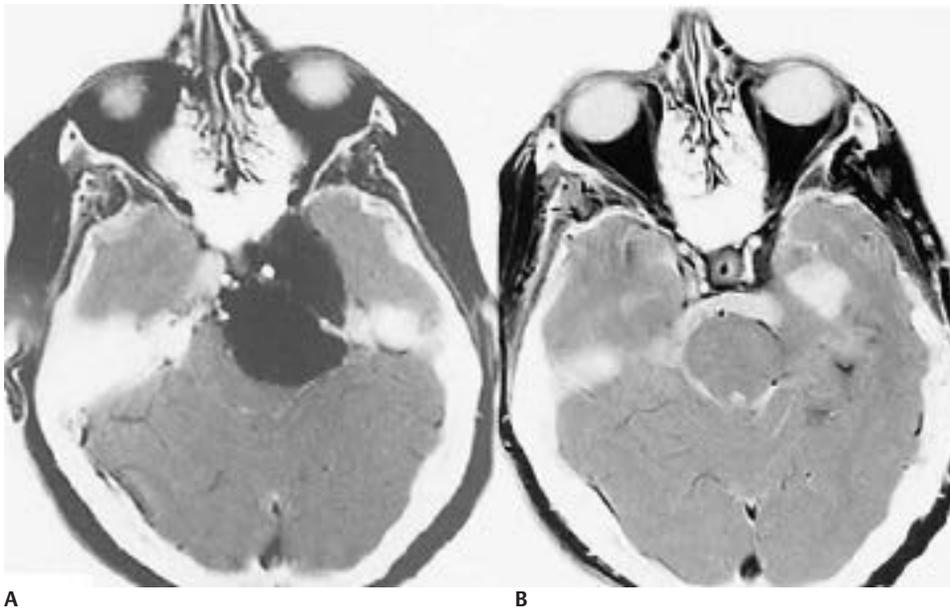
A sphenopetroclival meningioma with invasion of the cavernous sinus. A skull base approach facilitated total removal. (A) Preoperative enhanced axial MRI. (B) Postoperative axial magnetic resonance imaging.
